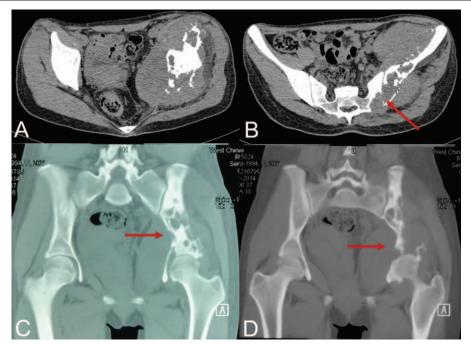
CT scans of the patient. (A) Showing left pelvic acetabular involvement with a huge soft-tissue mass. (B) Showing sacroiliac joint and left sacrum was destructed. (C) Showing the lytic lesion spreading form left ilium to sacroiliac joint. (D) Showing severe lytic destruction lead to a high risk of pathologic fracture.
